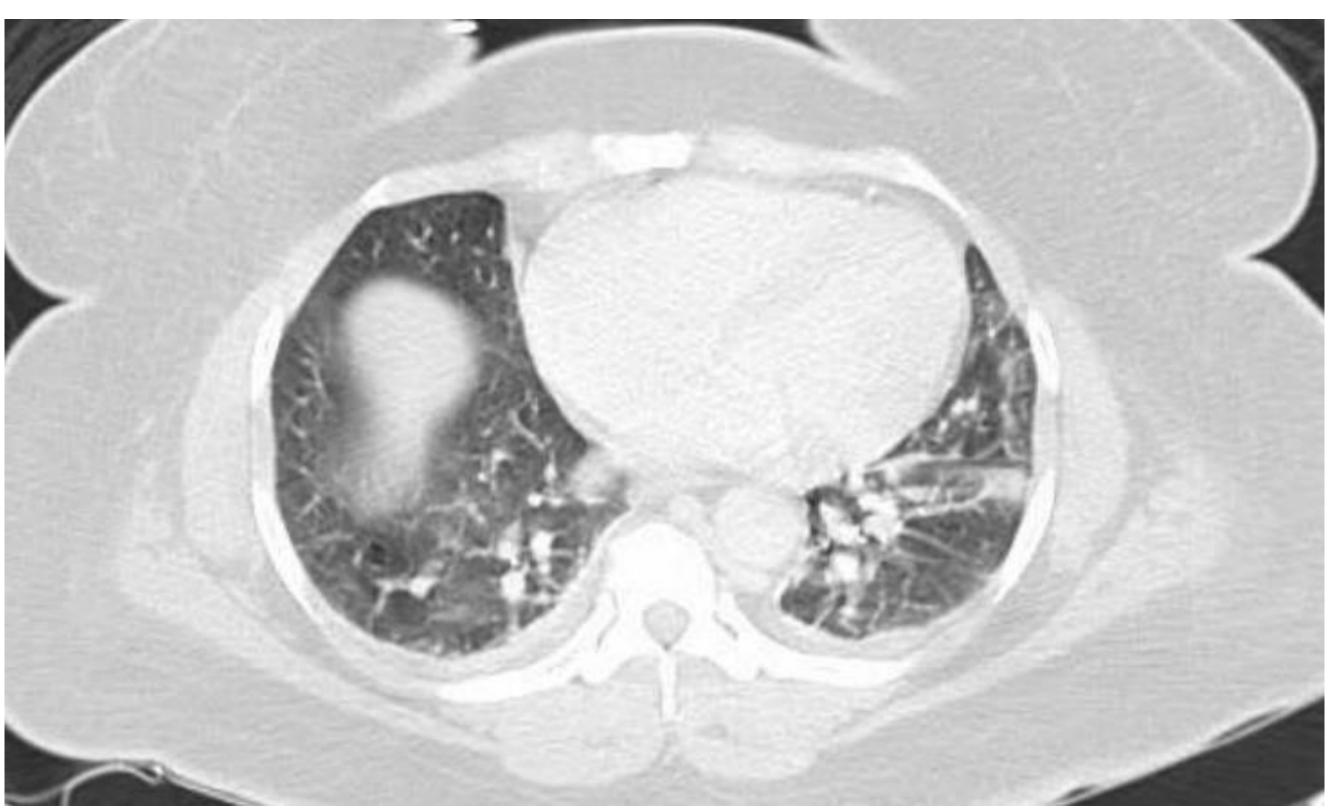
Mild septal thickening, diffusely enlarged lymph nodes and ground-glass opacities on patient's lung CT
